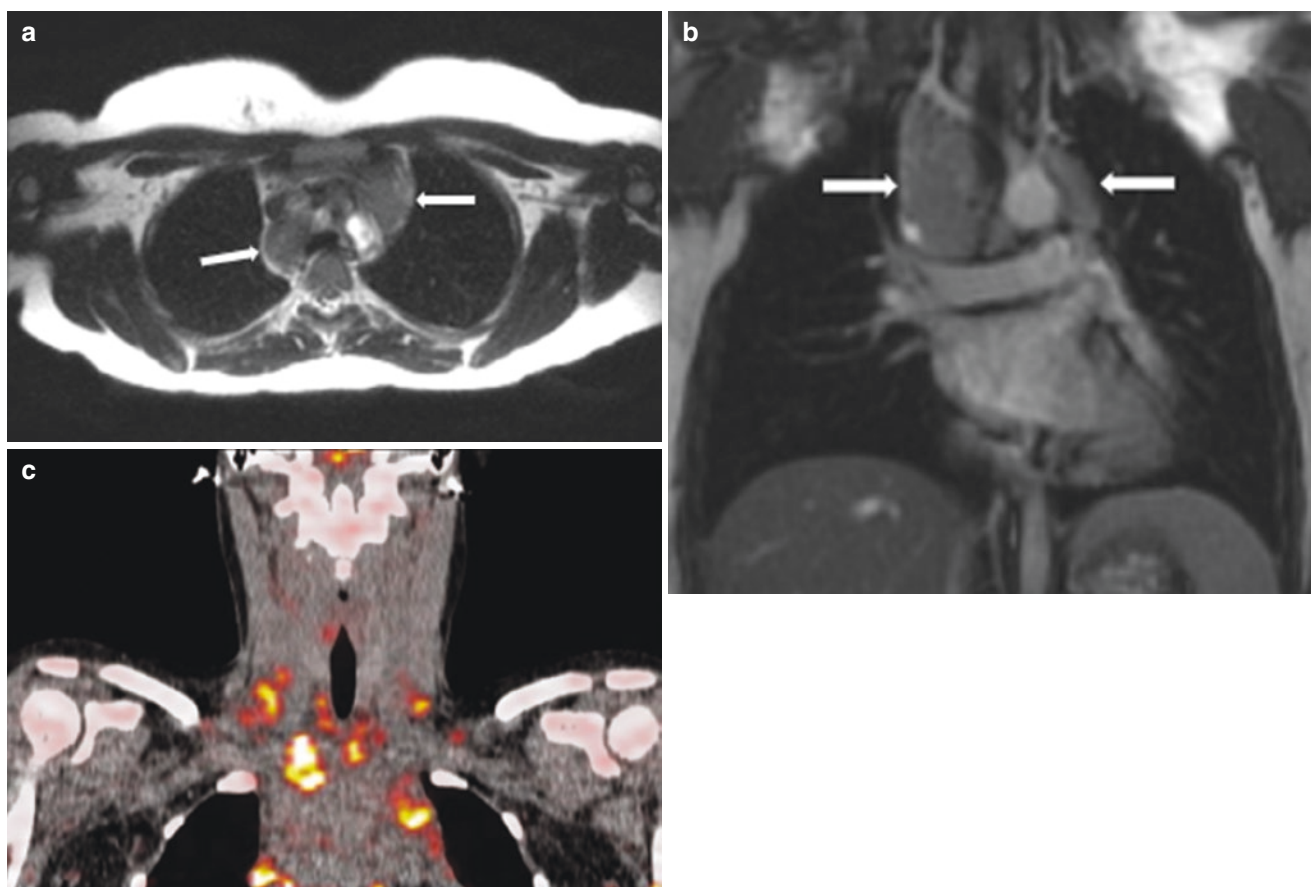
A 12-year-old girl with Hodgkin lymphoma. (a) Axial T2-weighted HASTE MR image shows mediastinal lymphadenopathy (arrows). (b) Coronal contrast-enhanced T1-weighted FIESTA MR
